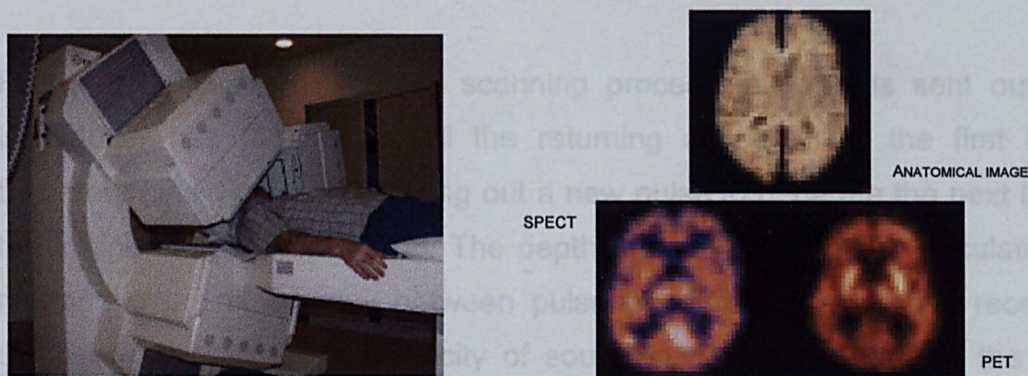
LEFT: SPECT scanner with 3 detector heads, (Suetens, 2001) (p120). RIGHT: Comparison among anatomical image and nuclear imaging methods (Montandon and Zaidi, 2002).
